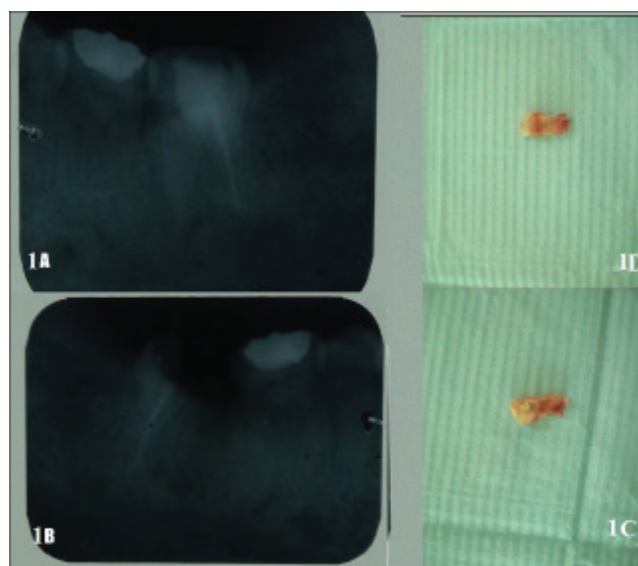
Pre-op radiograph (A), Retained distal root after hemisection (B), Distal view of mesial root (C), Mesial view of mesial root (D).
